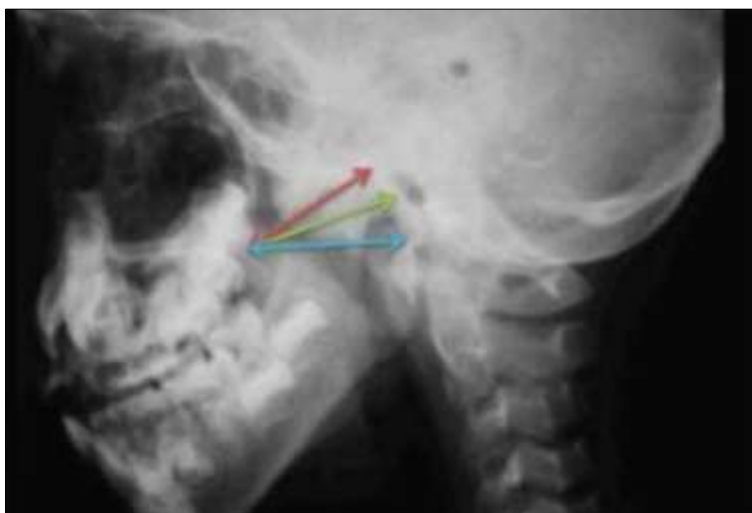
X-ray of nasopharynx with reference lines
